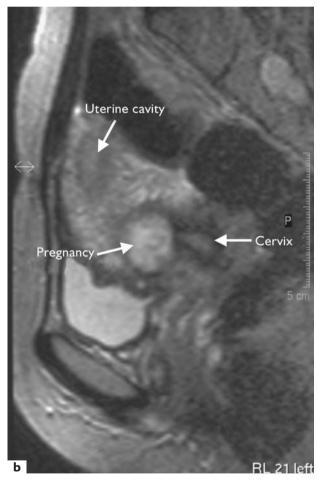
(a) Magnetic resonance imaging (MRI): transverse section clearly demonstrated the pregnancy (arrow) implanted in the anterior portion of the cervix, outside the endocervical canal. R, rectum; B, bladder. (b) Sagittal section demonstrated the pregnancy implanted in the anterior portion of the cervix. The cervical canal as well as the uterine cavity are clearly visible
